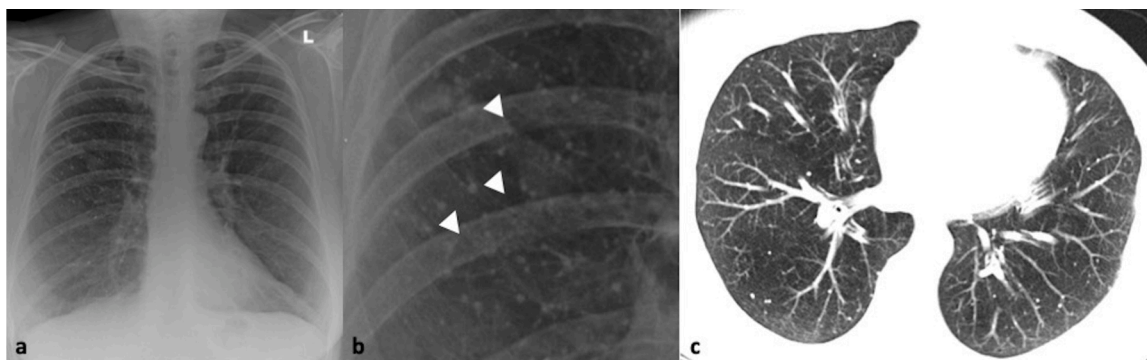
35-year-old male with healed varicella-zoster infection. 13a, b. Chest x-ray and close-up view shows multiple, bilateral and randomly distributed tiny calcified nodules (arrowheads). 13c. Axial CT image confirms the findings of the chest radiograph.
